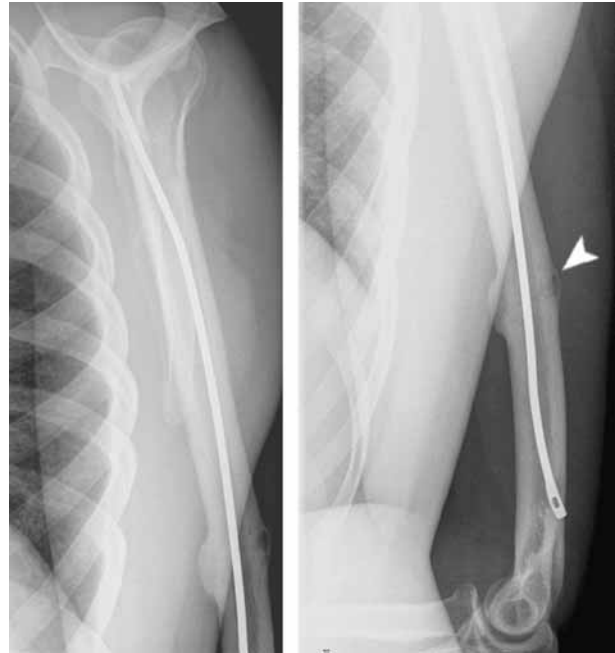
Radiographic findings at nine months: The osseous tunnel through the callus is apparent on both frontal and lateral views.
